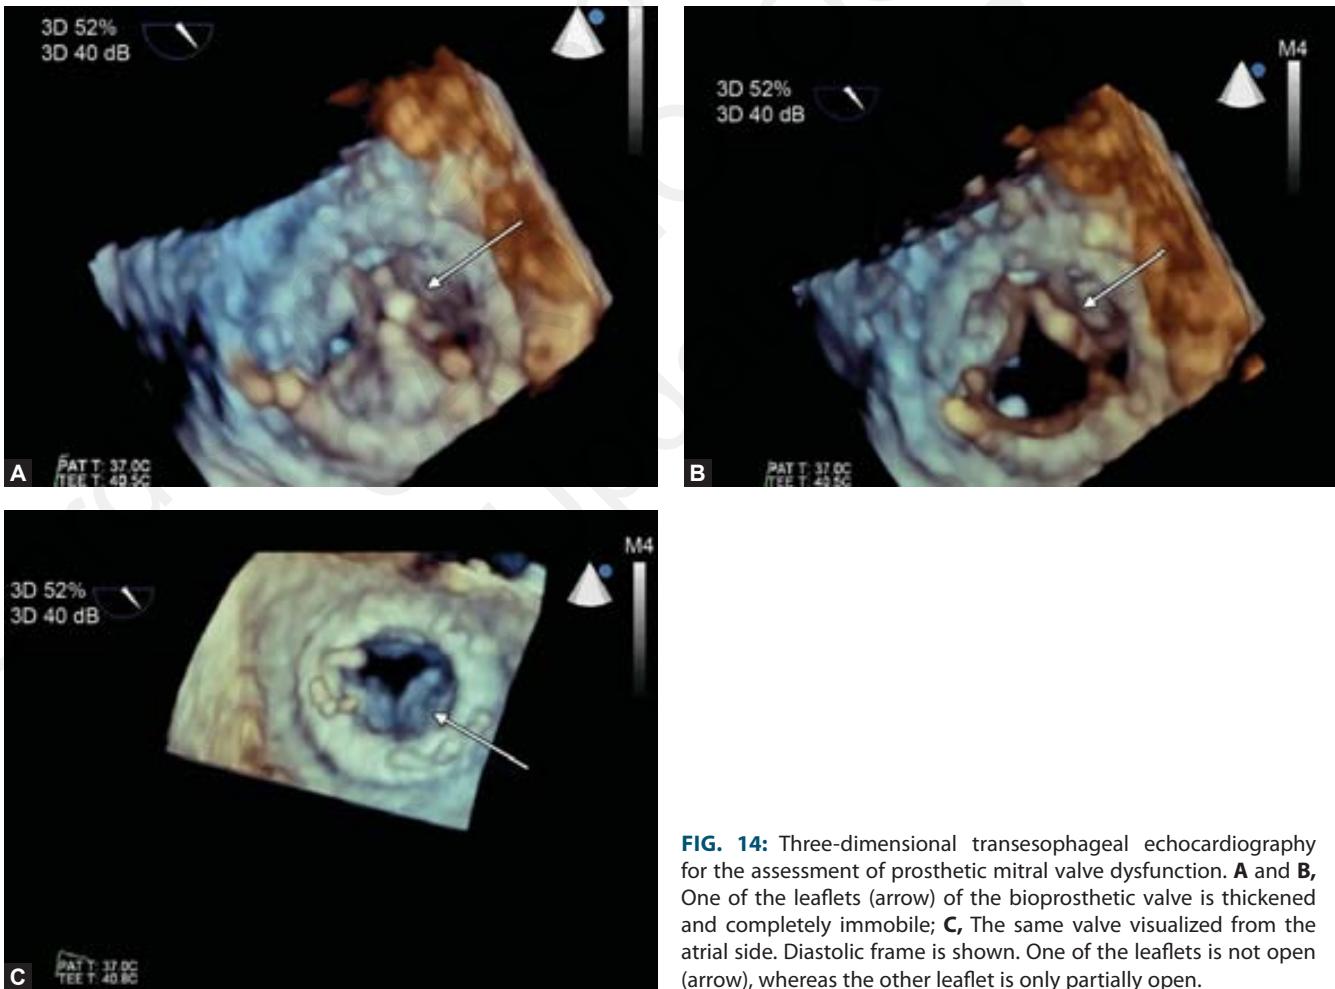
Three-dimensional transesophageal echocardiography for the assessment of prosthetic mitral valve dysfunction. A and B, One of the leaflets (arrow) of the bioprosthetic valve is thickened and completely immobile; C, The same valve visualized from the atrial side. Diastolic frame is shown. One of the leaflets is not open (arrow), whereas the other leaflet is only partially open.
